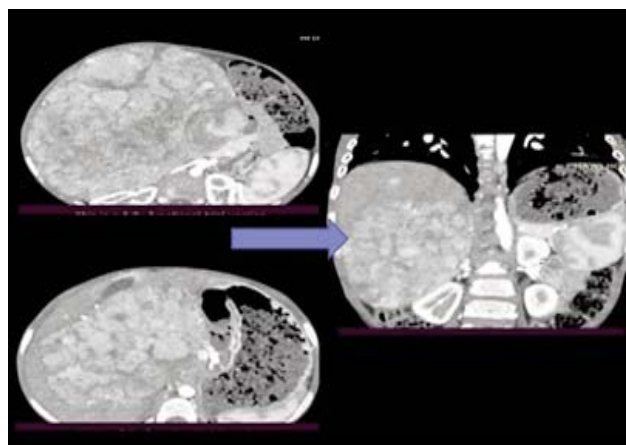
Abdominal Computed Tomography (CT) showing a large heterogeneously enhancing mass in the right suprarenal region.
